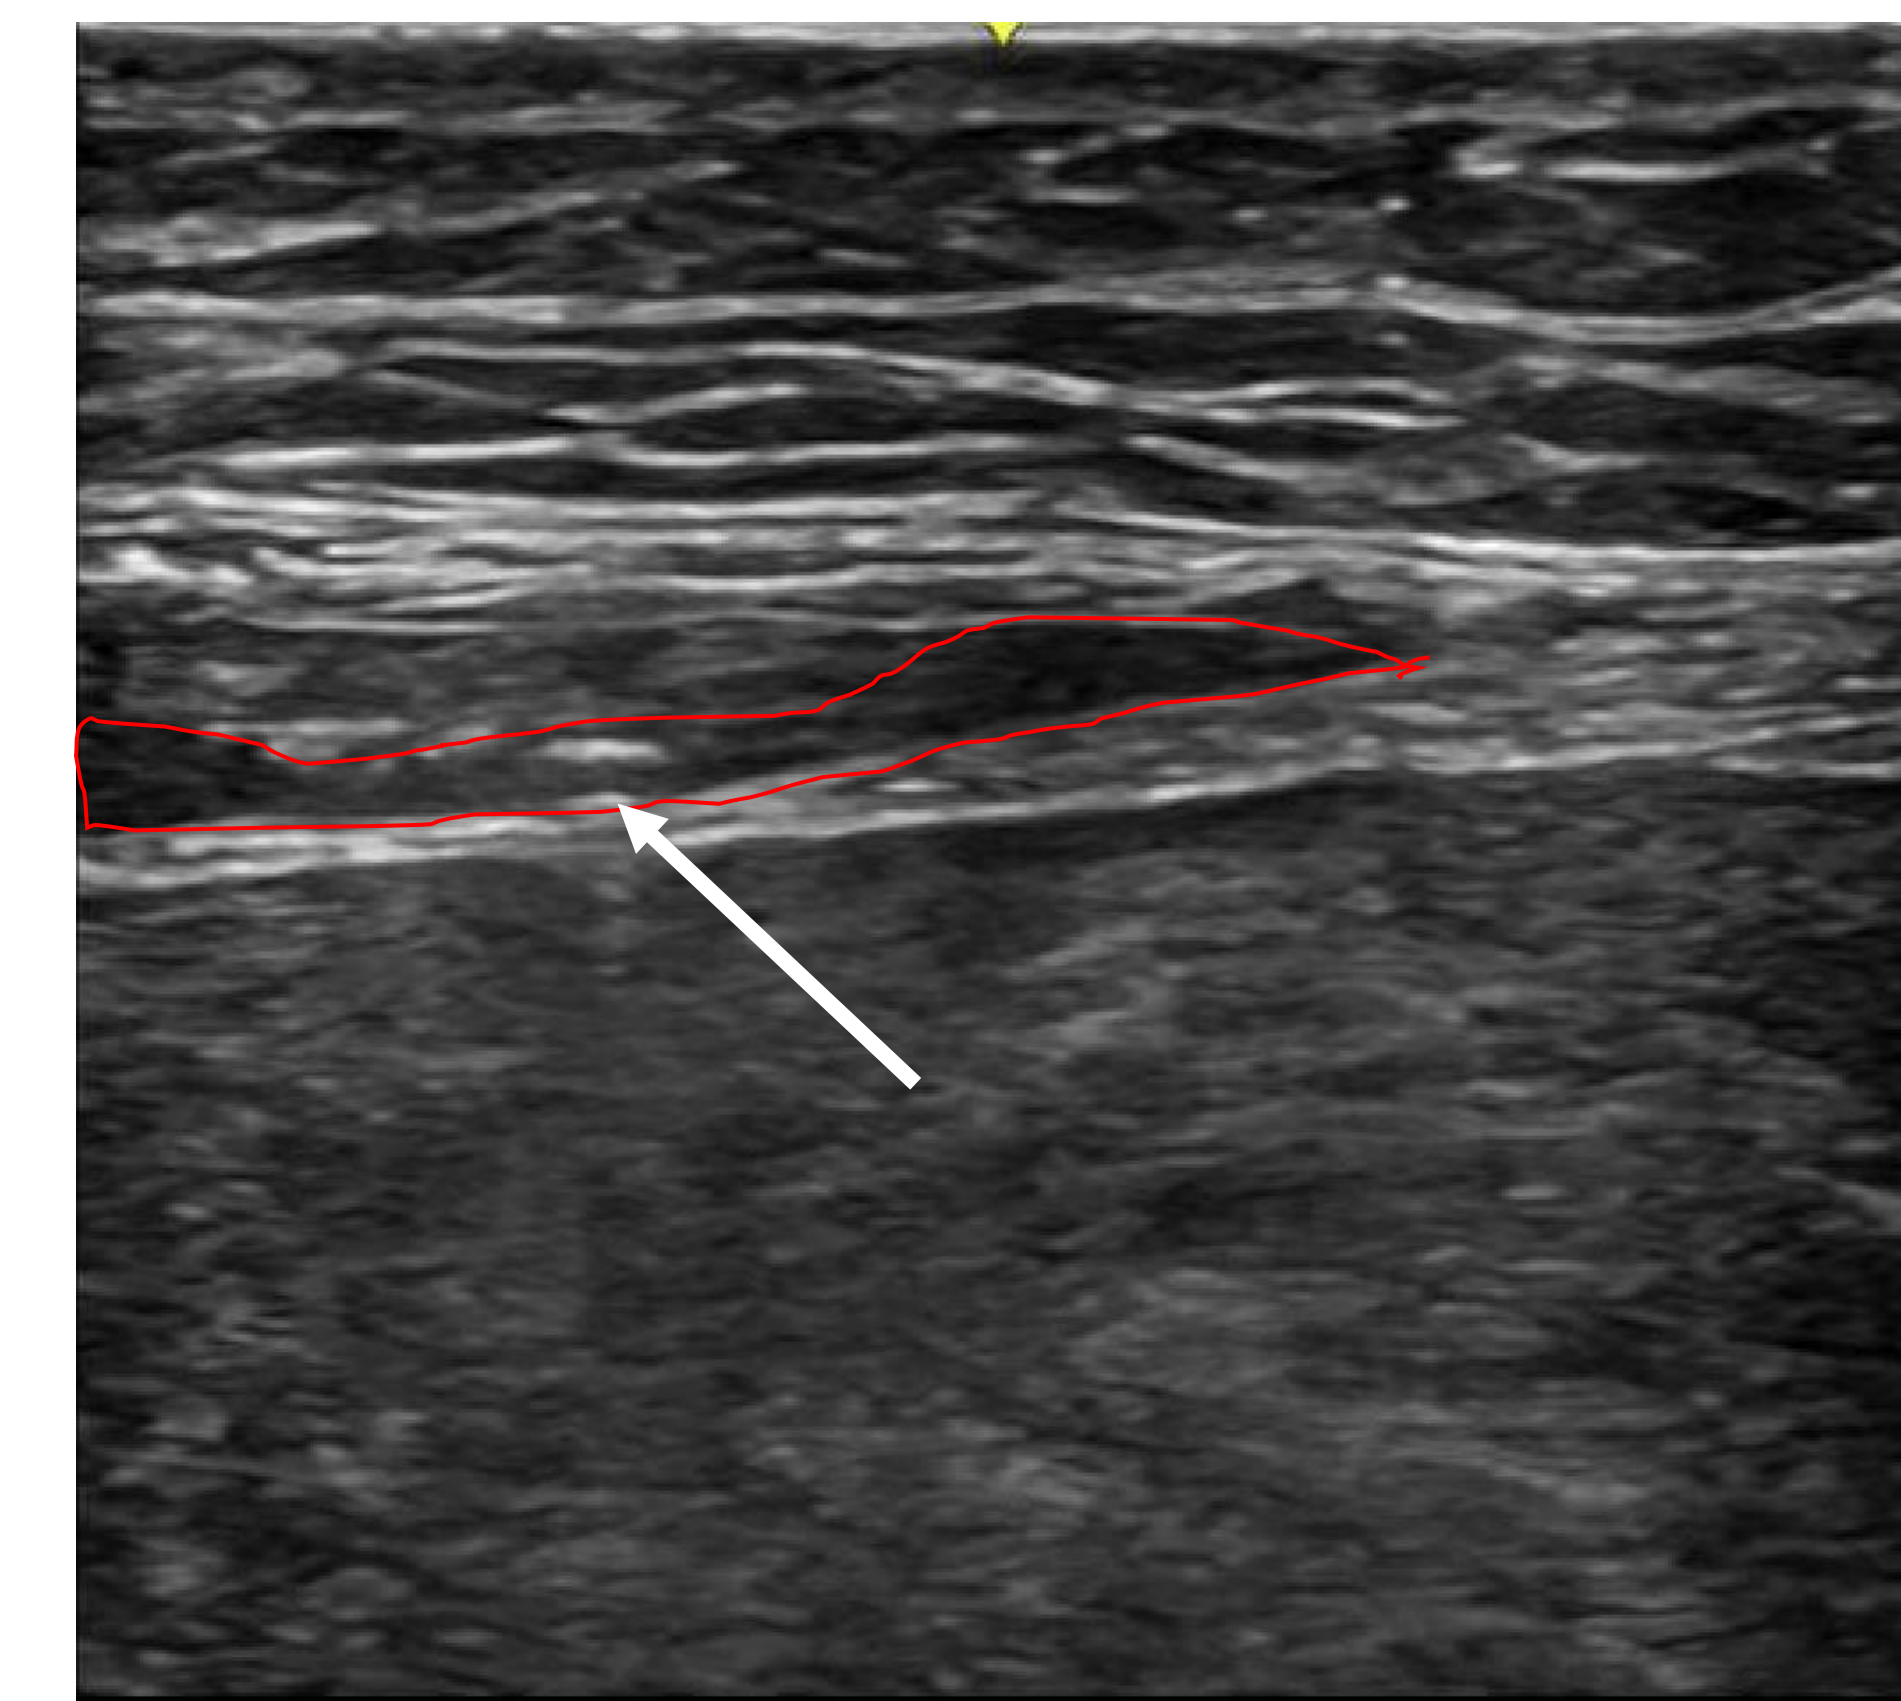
Out of plane needle view (arrow) with local anesthetic spread (red). Despite patient's unique anatomy, ultrasound-guided rectus sheath blocks were uncomplicated.
